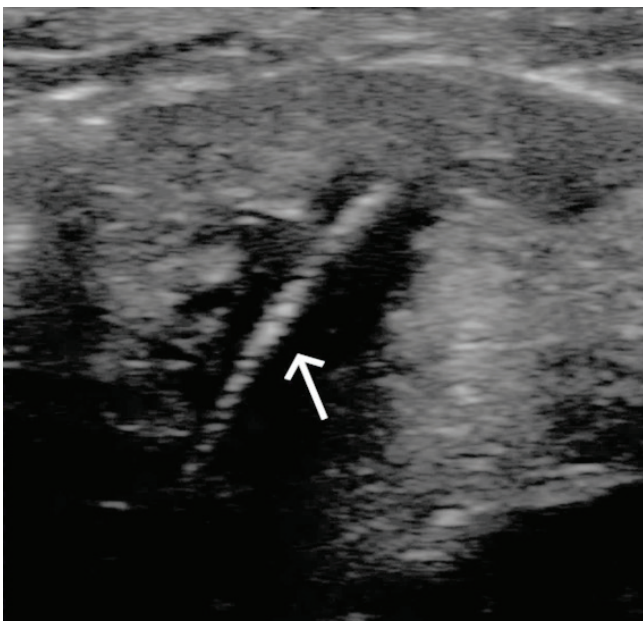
The ultrasound image is suggestive of a foreign body, indicated by a white arrow
